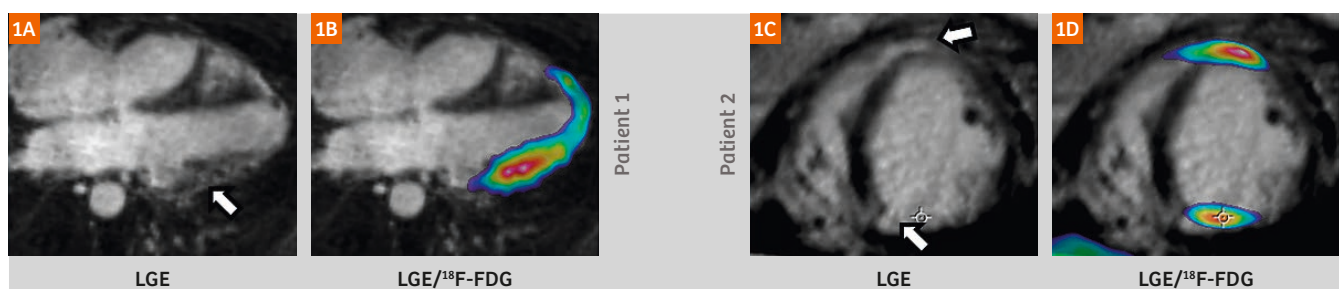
From left to right: (1A, C) LGE MR images showed elevated LGE signal at the lateral and anteroseptal wall for patient 1 (62-year-old male) and patient 2 (63-year-old female) respectively. (1B, D) Matched ^{18}F -FDG PET fused with previous LGE MR images showed high ^{18}F -FDG uptake overlapping with the LGE pattern of injury.
